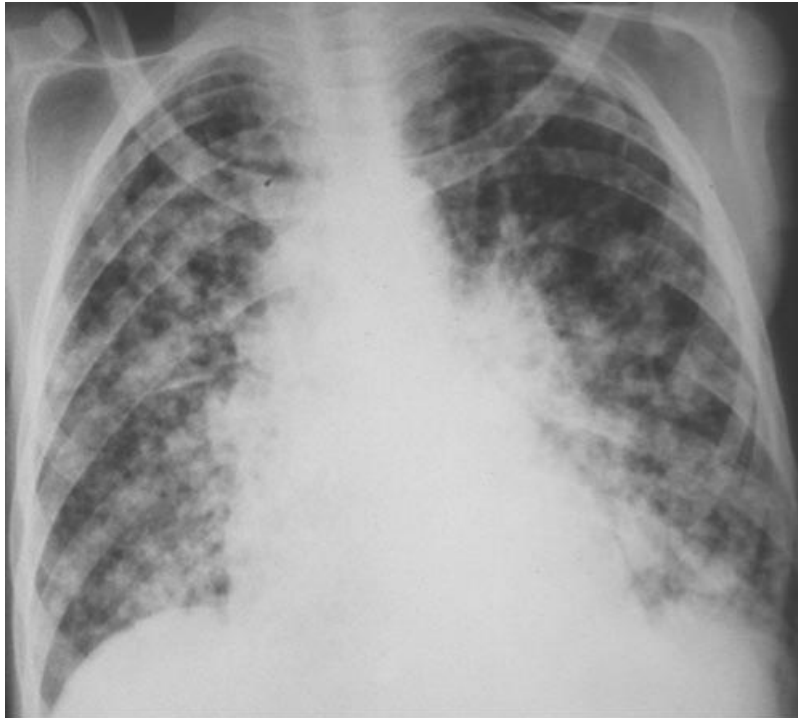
PA Chest X-ray of HIV - positive PTB subject that shows bilateral diffuse reticulonodular and patchy opacities involving both lung fields
